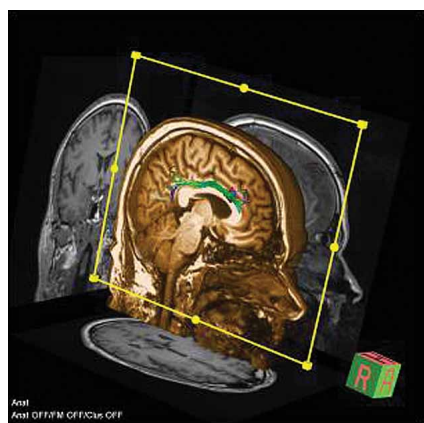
Figure shows diffusion tensor magnetic resonance imaging (DT-MRI) tractography of cingular gyrus in forensic patient. Imaging is performed in order to analyse possible abnormalities within the limbic system in the brain (Figure obtained from Croatian Institute for Brain Research).
